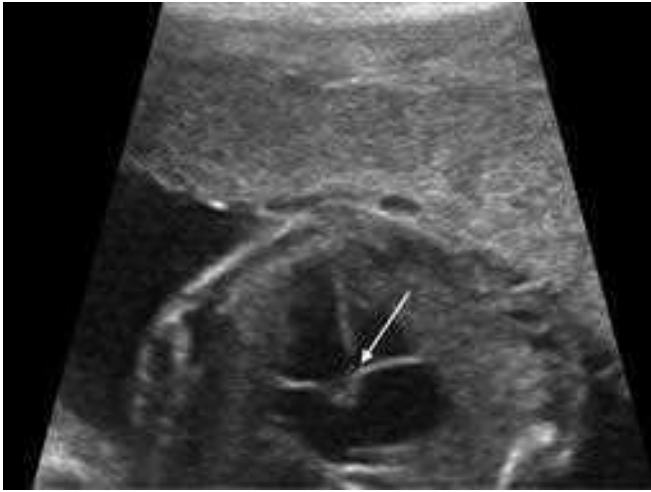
Fetal ultrasound showing ventricular septal defect
